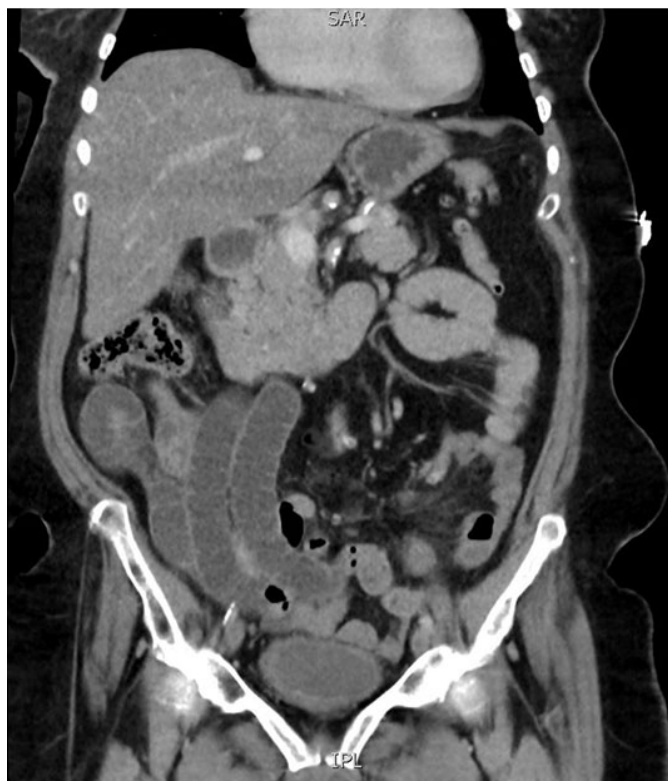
CT image of the abdomen demonstrating collapsed loop of small bowel in the left pelvis, and dilated small bowel in the right abdomen.
